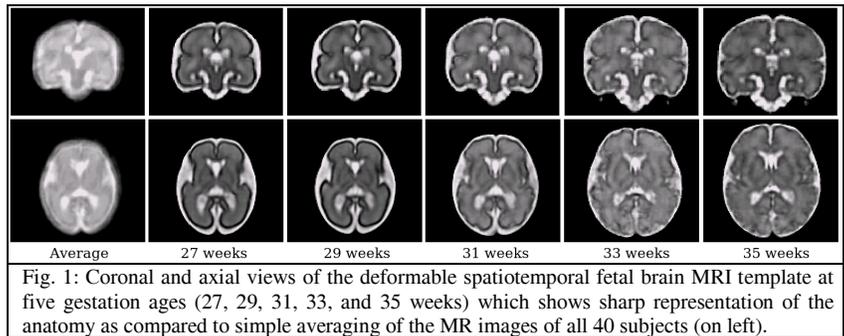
Coronal and axial views of the deformable spatiotemporal fetal brain MRI template at five gestation ages (27, 29, 31, 33, and 35 weeks) which shows sharp representation of the anatomy as compared to simple averaging of the MR images of all 40 subjects (on left).
